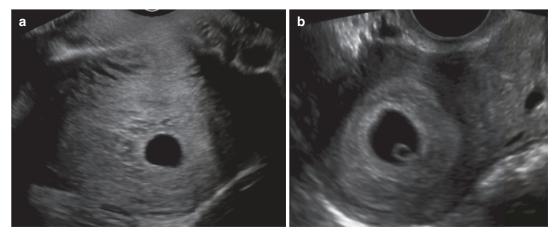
Empty gestational sac: 7 weeks 0 days transvaginal sagittal and transverse images show an intrauterine gestational sac with MSD 19.5 mm. No yolk sac or fetal pole is identified. These findings are suspicious but not diagnostic for early pregnancy loss as the MSD is <25 mm. Findings should be reported as an early intrauterine pregnancy of unknown viability and follow-up scan performed not, however, be considered diagnostic criteria for early pregnancy loss with 100% specificity. Consequently, the use of a single discriminatory  $\beta$ -hCG level to guide management in the setting of pregnancy of unknown location (PUL) is not recommended [32, 34]. There is emerging evidence that the incremental increase in serum  $\beta$ -hCG over 48 h, expressed as a ratio, may be a useful predictor of IUP when ultrasound findings are inconclusive [35–37].  $\beta$ -hCG levels obtained 48 h apart should typically double, i.e., increase 100%. Various thresholds can be used to achieve greater diagnostic certainty with a rise of <67% predictive of an abnormal outcome with 95% certainty and a rise of  $\leq$ 35% predictive of an abnormal pregnancy with 99.9% certainty [38–40]. Bignardi et al. [35] have reported that a  $\beta$ -hCG ratio >2.0 is suggestive of a viable IUP with sensitivity of 77%, specificity of 96%, and a positive predictive value of 87%. However, the use of  $\beta$ -hCG ratio as a predictor of viability in the setting of early pregnancy is not routine practice in all centers.
